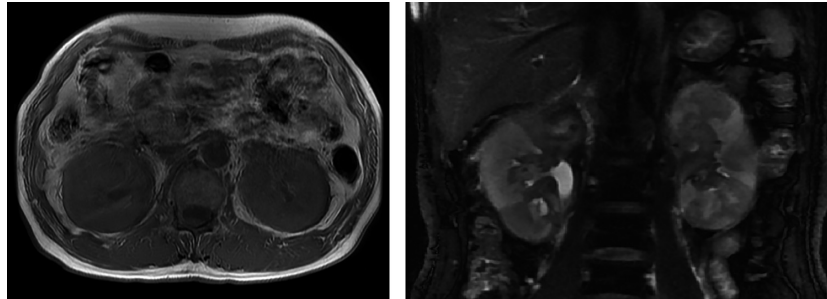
MRI showing kidney enlargement and bilateral renal multiple tumors, with low intensity on T1- and T2-weighted images.
